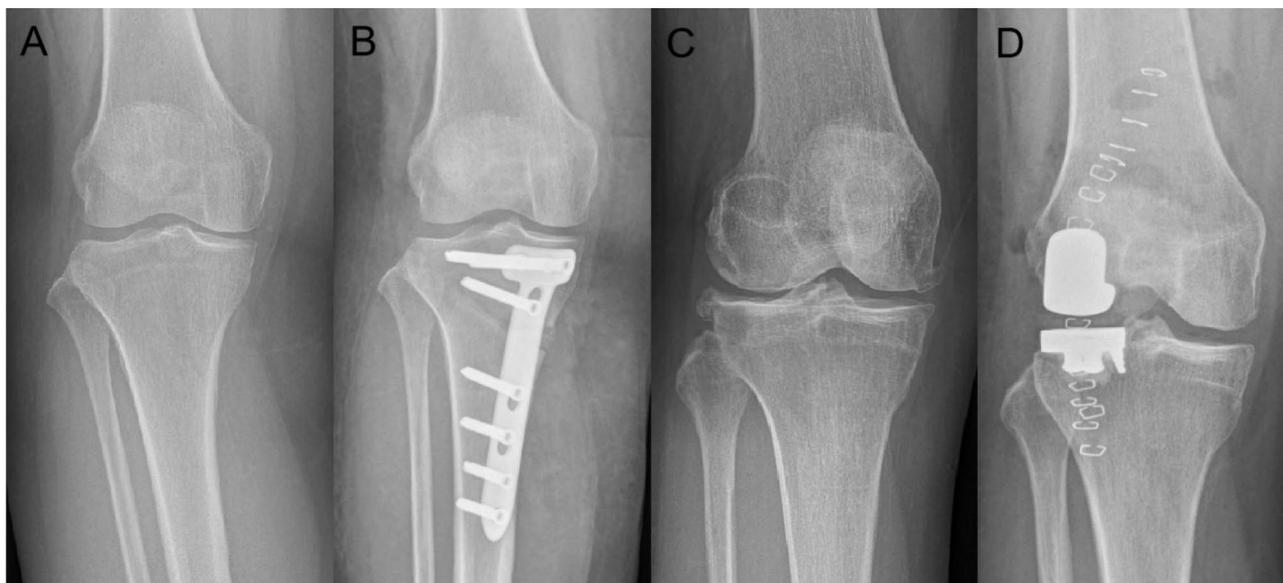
Radiographic evaluation of HTO. (A) Preoperative anteroposterior view and (B) Postoperative Lateral view. Radiographic evaluation of UKA. (C) Preoperative anteroposterior view and (D) Postoperative Lateral view
